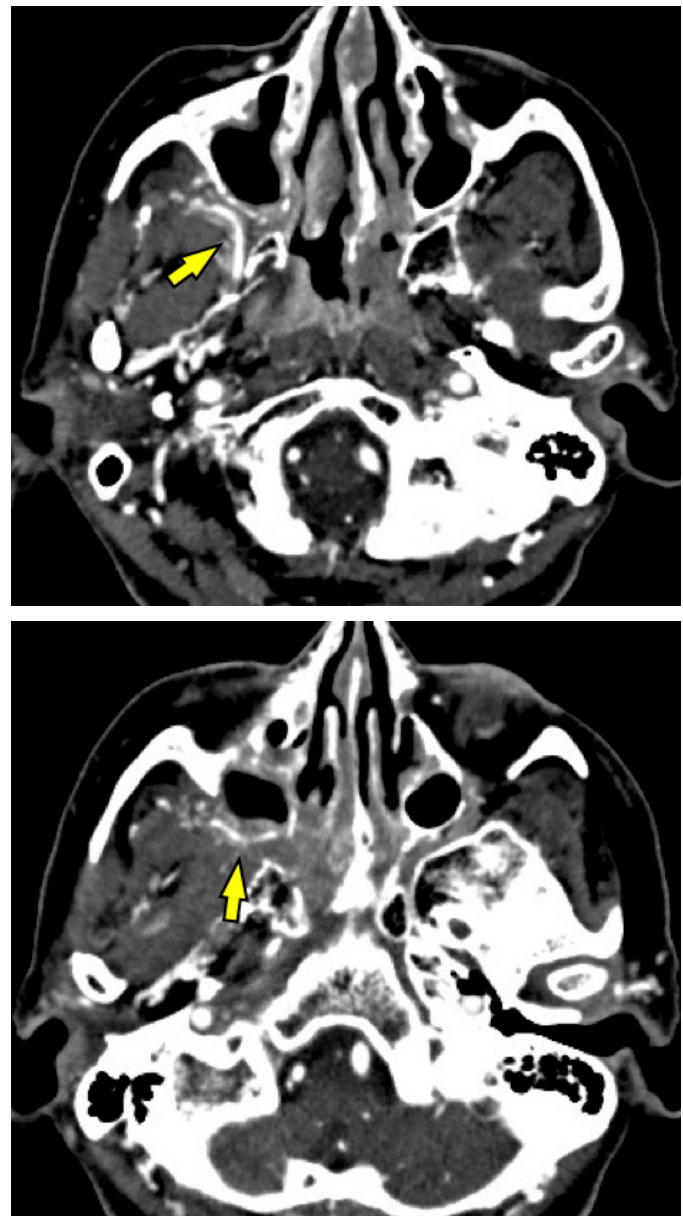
CT angiography showing the maxillary artery (arrow) running through the PPF lesion in the arterial phase.
